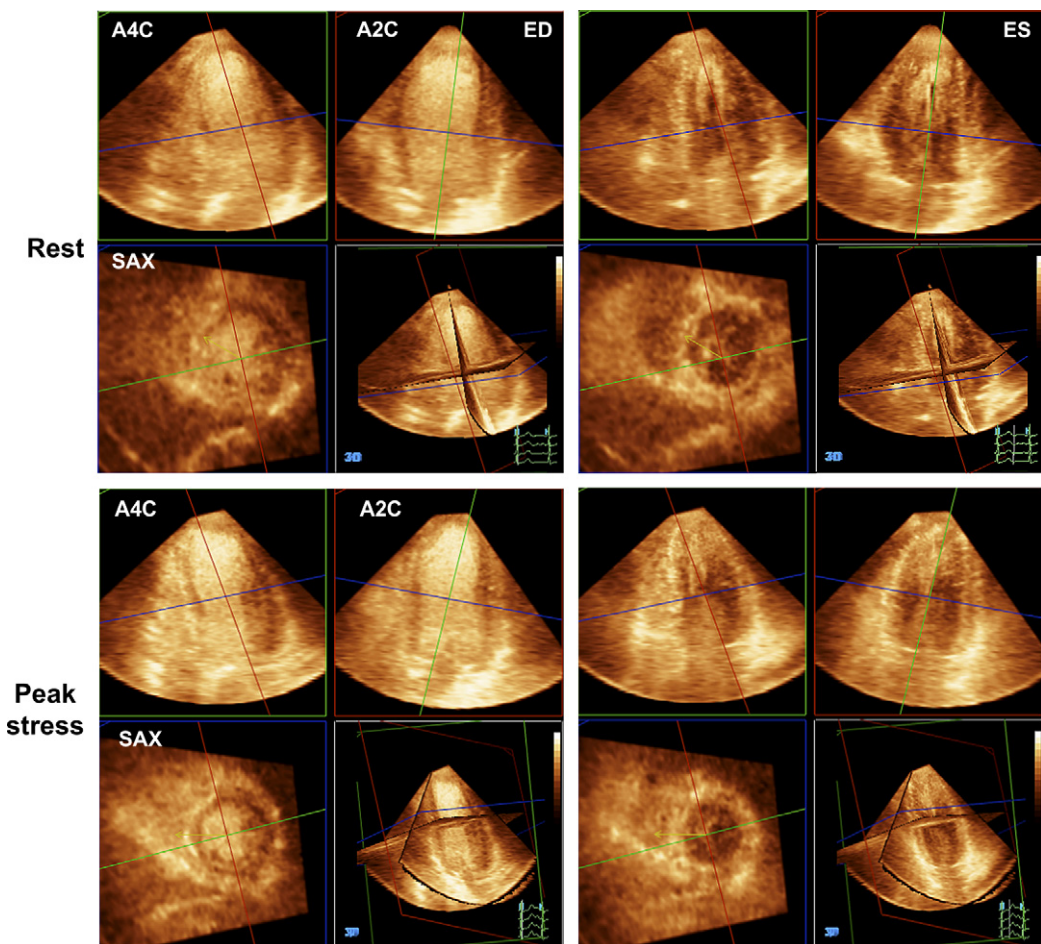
Cropped image from full-volume datasets obtained during dobutamine stress echocardiography. Upper panels show baseline images, while the lower panels depict images obtained during peak dobutamine infusion. Simultaneous multiple cut plane images (apical four-chamber, two-chamber, and short-axis views) can be cropped from the full-volume datasets (left, end-diastole; right, end-systole).
